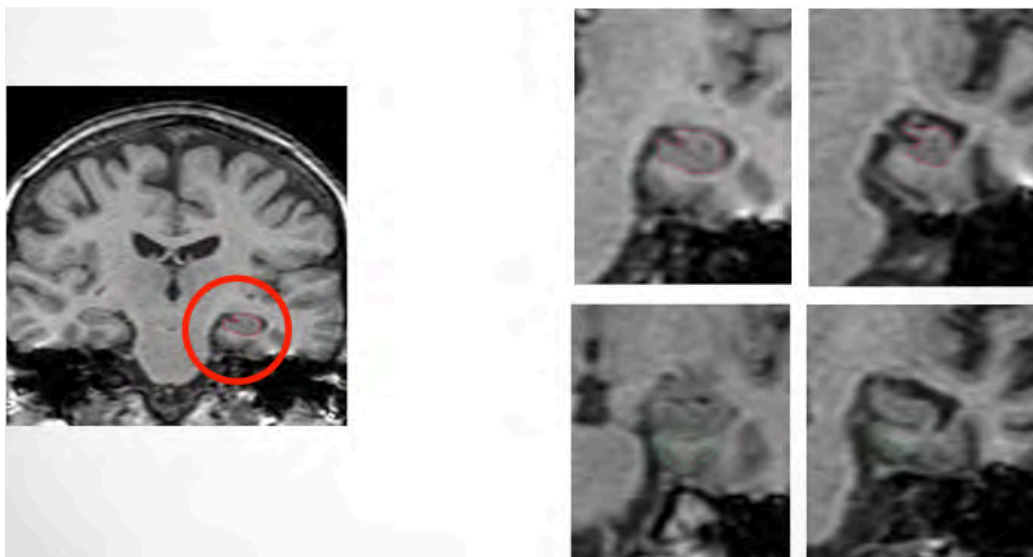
Coronal section at the level of the hippocampus and entorhinal cortex. The image on the left shows a normal hippocampus as seen on T1W MRI. The images on the inside right show a normal hippocampus and EC (upper and lower images respectively) compared to atrophic changes seen in AD (outside right)
